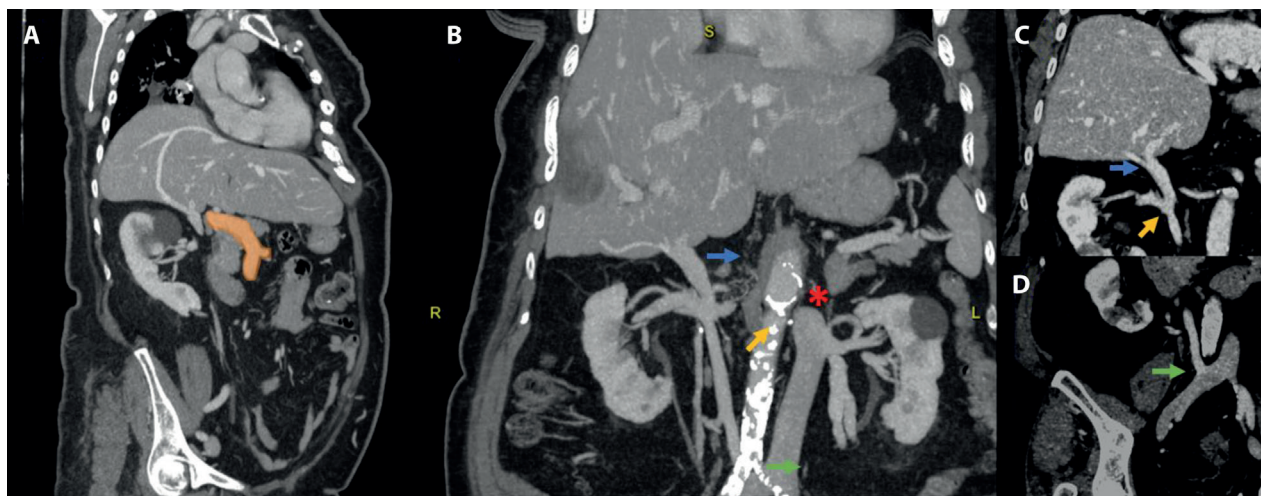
Portal phase of Whole-Body CT scan. a) curved reformatted image of the transhepatic continuation of one of the suprahepatic veins. There was no shunt with the portal system, as there was no communication with the splenic-portal axes (colored in orange) b) showed the anomalous vein originating from the right common iliac vein, the confluence of the right renal vein, and the azygos vein, the transhepatic continuation. c) and d) showed respectively the origin from the right common vein and the continuation in the liver. Green arrow: origin; Yellow arrow: confluence; Blue arrow: transhepatic continuation; Red asterisk: azygos vein.
